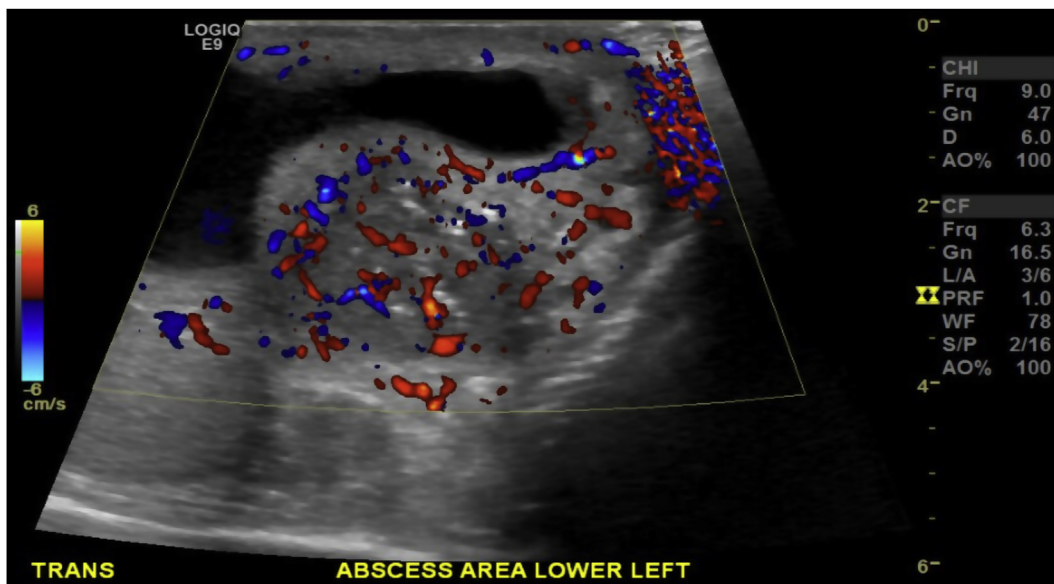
Doppler ultrasound of scrotum, left testicle.
